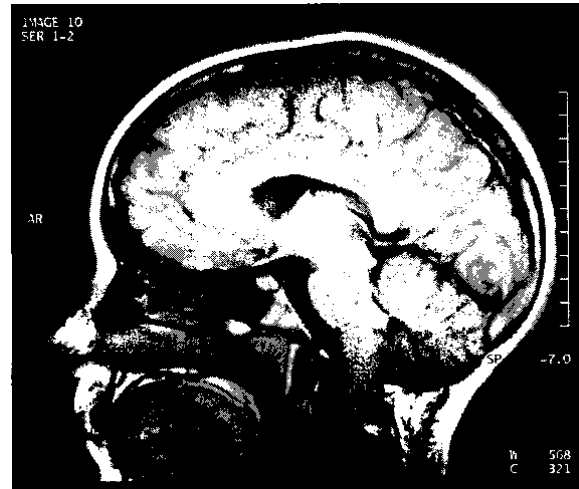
Case 4 at language testing (6 years 3 months post treatment): Sagittal MRI scan demonstrating tumour stability post surgery treatment for brainstem tumour, with no progression or evidence of new disease.
